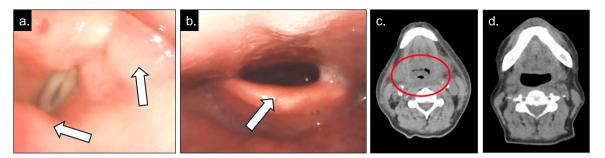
Laryngeal fiber (a, b) and CT scan (c, d) of case 1. Subcutaneous edema and swelling of epiglottis and pharynx were observed by laryngeal fiber scope (arrows, a, b) and CT scan (circle, c). Improvement of airway constriction with corticosteroid therapy was observed (d).
